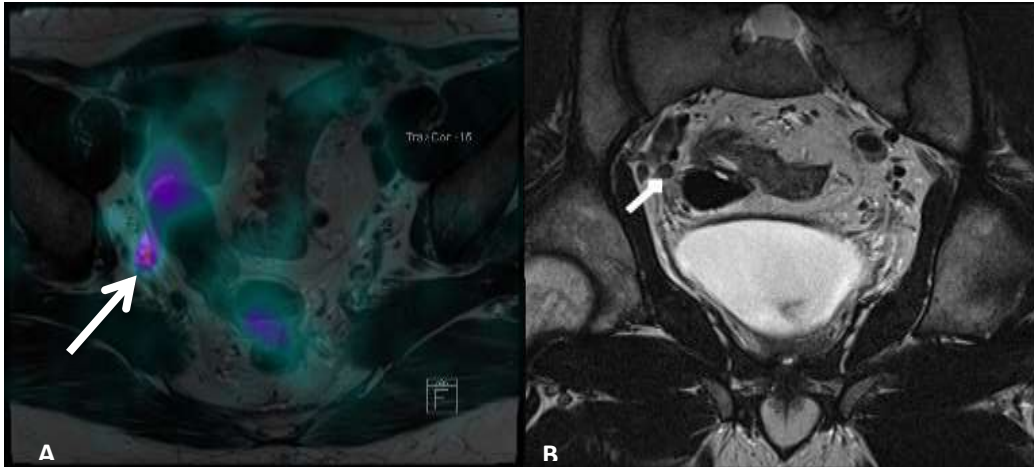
Patient BCR015 demonstrating evidence of local recurrence on imaging; (A) Extensive recurrence within prostate gland, demonstrated on PSMA PET MRI (B) T2 weighted MRI component showing concordance with PSMA PET, demonstrating recurrent lesion (white arrows).
